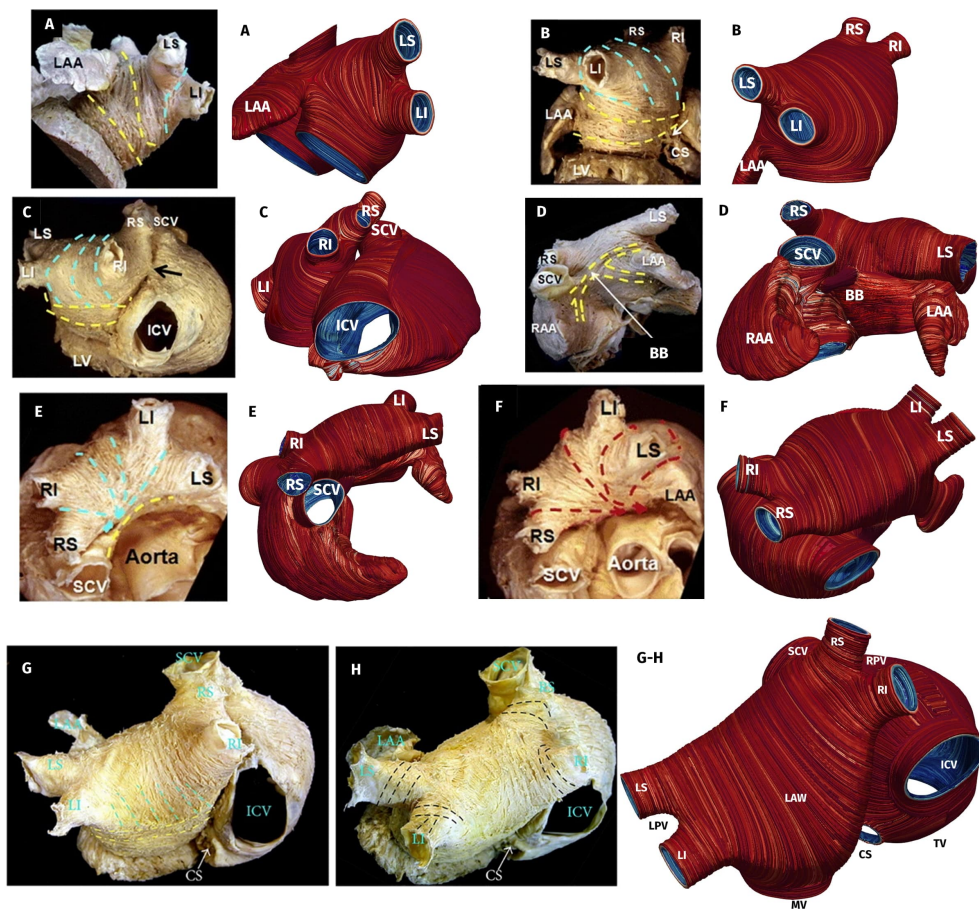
Comparison between anatomical atrial dissections in a normal human atria and fibers obtained by the atrial LDRBM in the Riunet and Zygote geometries. Fiber orientations, displayed with dashed lines in anatomical pictures, are compared with fiber generated by the atrial LDRBM rules (R1-R7). ICV, SCV: inferior and superior caval veins; CT: crista terminalis; CS: coronary sinus; LV: left ventricle; TV, MV: tricuspid and mitral valve rings; LPV: left pulmonary superior (LS) and inferior (LI) veins; RPV: right pulmonary superior (RS) and inferior (RI) veins; BB: Bachmann's Bundle. Anatomical pictures are readapted from [100, 51, 97, 212].
